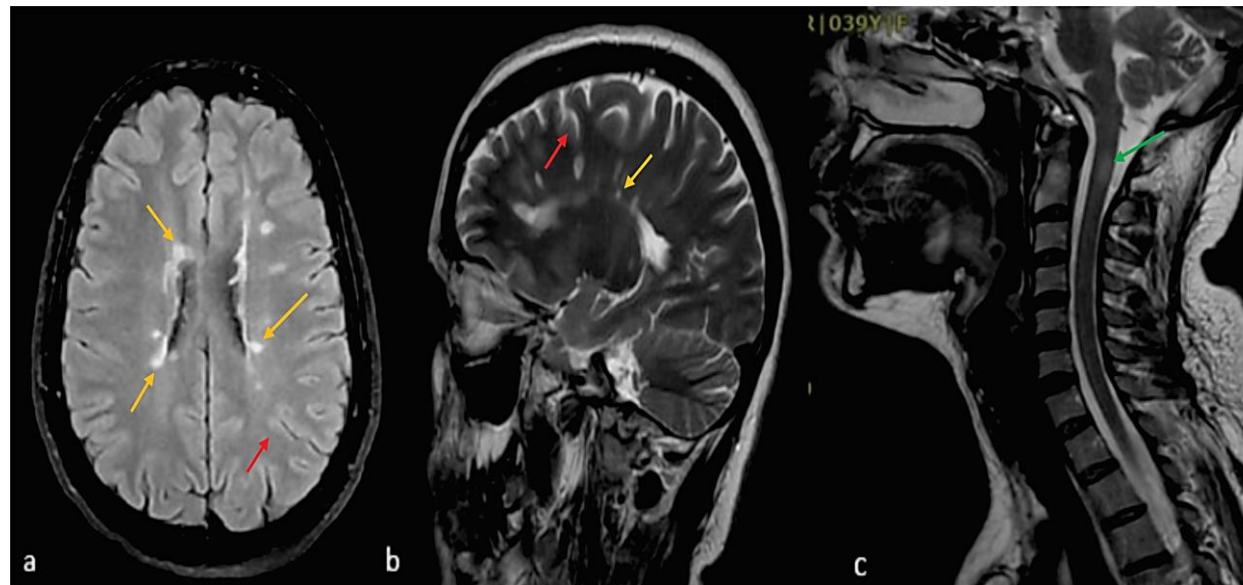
Patient 3; (a, b) multiple ovoid hyperintense lesions predominantly in juxtacortical (red arrows) and periventricular (yellow arrows) locations in axial T2-weighted fluid-attenuated inversion recovery (FLAIR) (a) sagittal T2, (b) sequences, (c) small T2 higher cervical hyper-intense lesion (green arrow) in the sagittal image
